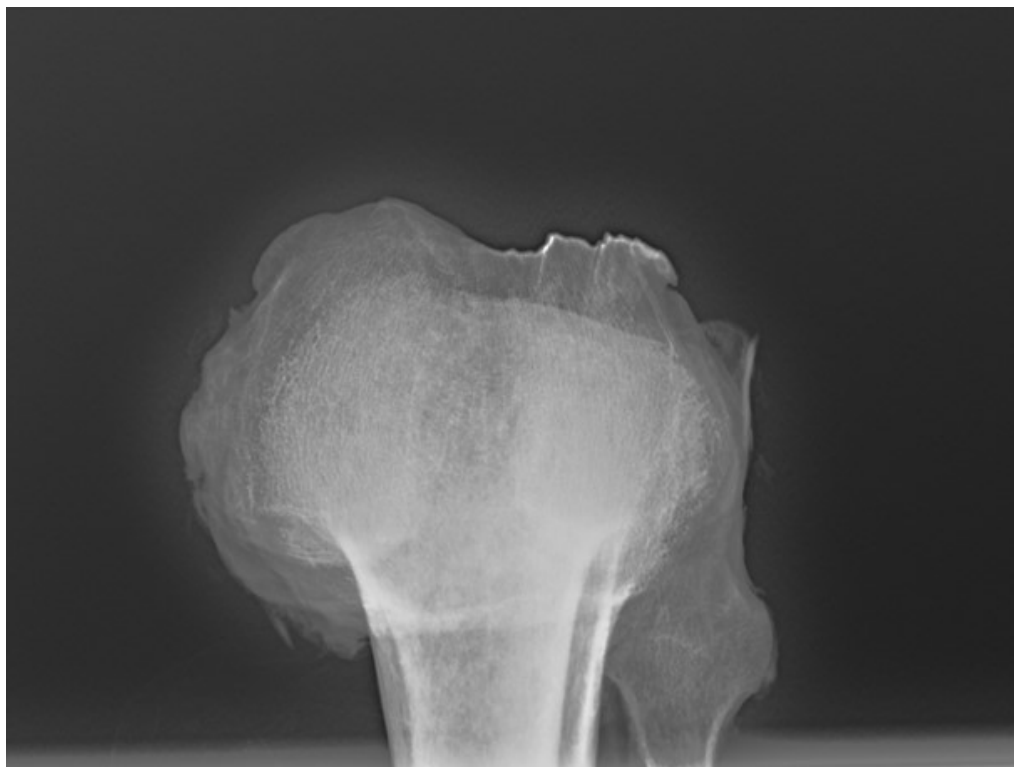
Radiographic image of the left knee with the patella removed demonstrating the cogwheel grooves observed on the lateral femoral condyle.
